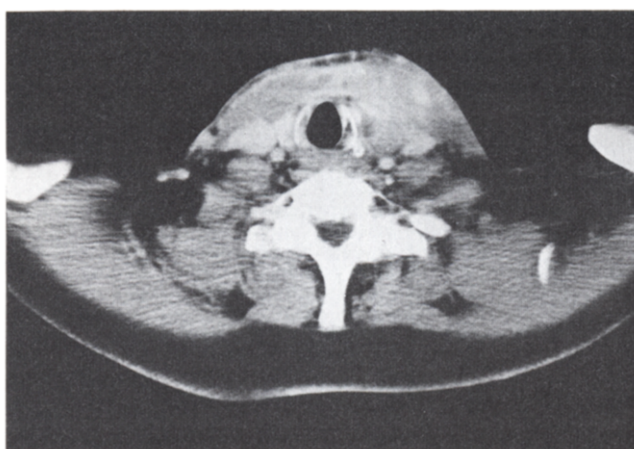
Computed tomography scan showing a mass on the left side of the neck invading sternomastoid muscle and inseparable from the vascular sheath with tracheal deviation to the right.
